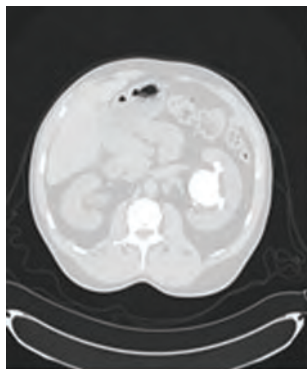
CT of staghorn calculous in patient with XGP
